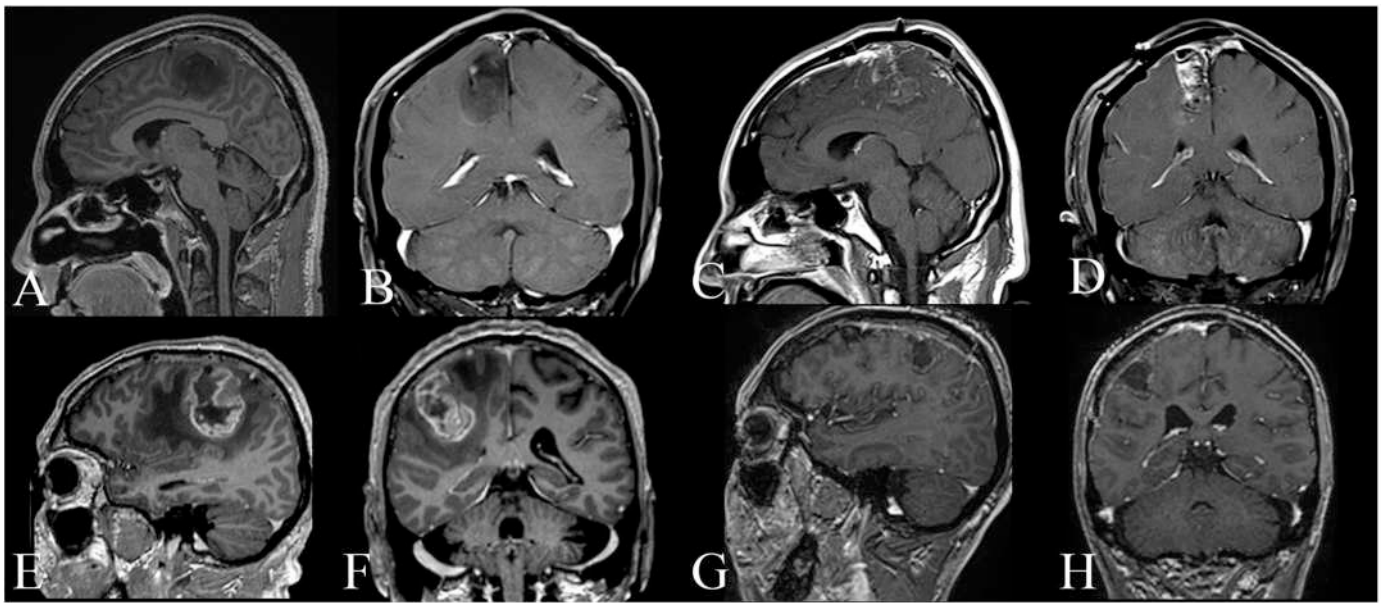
Pre- and postoperative MRI scans. *Case #1.* (A, B) Preop MRI demonstrates an intra-axial M1 tumor with minimal enhancement after gadolinium administration. (C, D) Immediate postoperative sagittal and axial images show a near-total resection. *Case #2.* (E, F) Preop MRI shows a right intra-axial M1 tumor, with heterogeneous enhancement after contrast administration and significant perilesional edema. (G, H) The 1-year follow-up MRI following adjuvant chemotherapy and radiotherapy demonstrated satisfactory tumor control.
